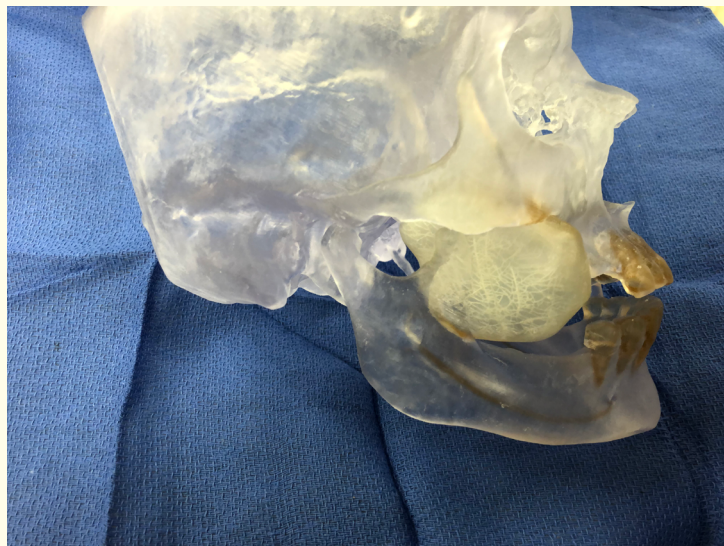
The CT scan displayed the outline of the lesion and, on her panorex, what appears to be an oval, slightly radiopaque area extending anteriorly to around tooth #4, superiorly nearing the level of the zygomatic arch, posteriorly to the posterior border of the ramus, and inferiorly to the level of the alveolar ridge of the mandible.
